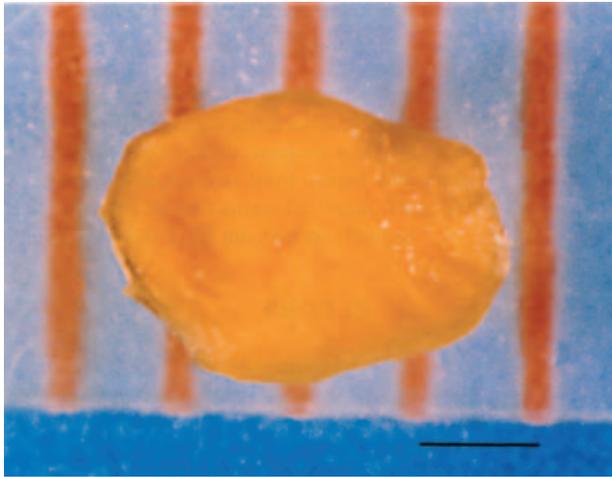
Sulfur granule from periapical lesion of tooth with refractory apical periodontitis. The granule is soft, yellowish in color and 3–4 mm in diameter. Three additional granules were recovered from the same lesion. From (66). Reproduced with permission from Lippincott, Williams & Wilkins.
